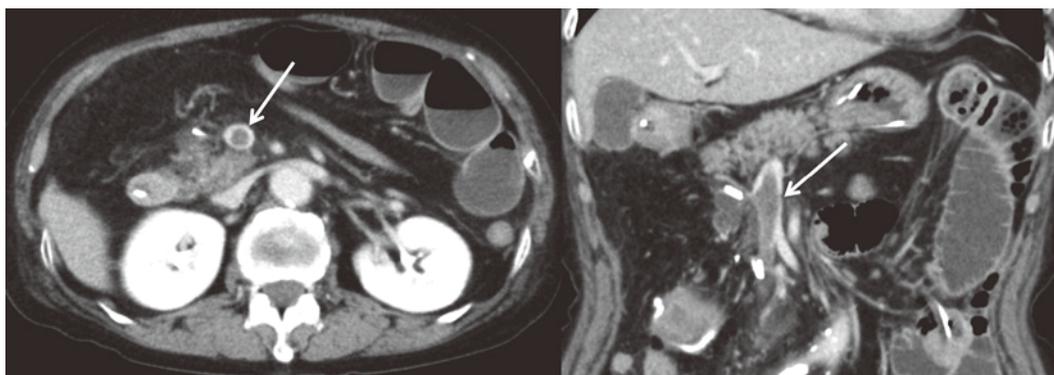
Computed tomographic images on postoperative day 12. Contrast-enhanced computed tomography showed a filling defect in the superior mesenteric vein (arrow) which ranged from bifurcation of the ileocolic vein to the confluence of the splenic and superior mesenteric vein. The maximum diameter was 11 mm. No distinct thrombus was observed in the portal vein.
